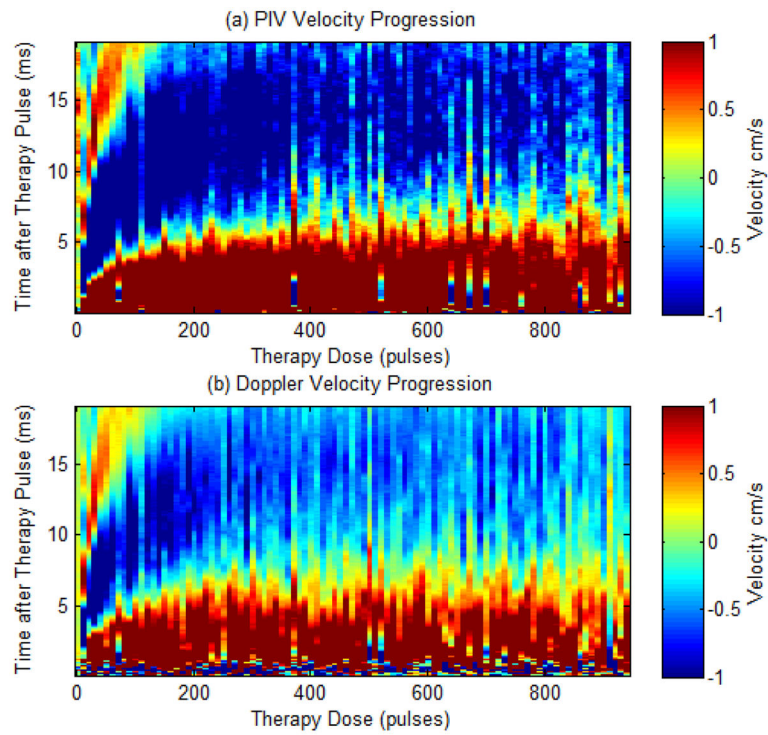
Comparison plots showing the velocity estimates from a single experiment as measured by PIV (a) and Doppler (b) after every 10 therapy pulses. The plots show velocity (color map) versus time after the therapy pulse (y-axis) over the course of therapy (x-axis).
